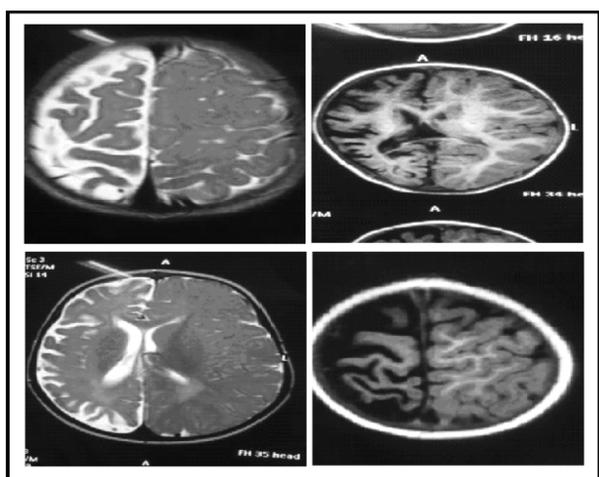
the MRI findings of our patient
